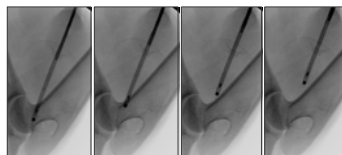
Sequence of x-ray images showing the x-ray probe in four positions within an implanted balloon during pullback.
